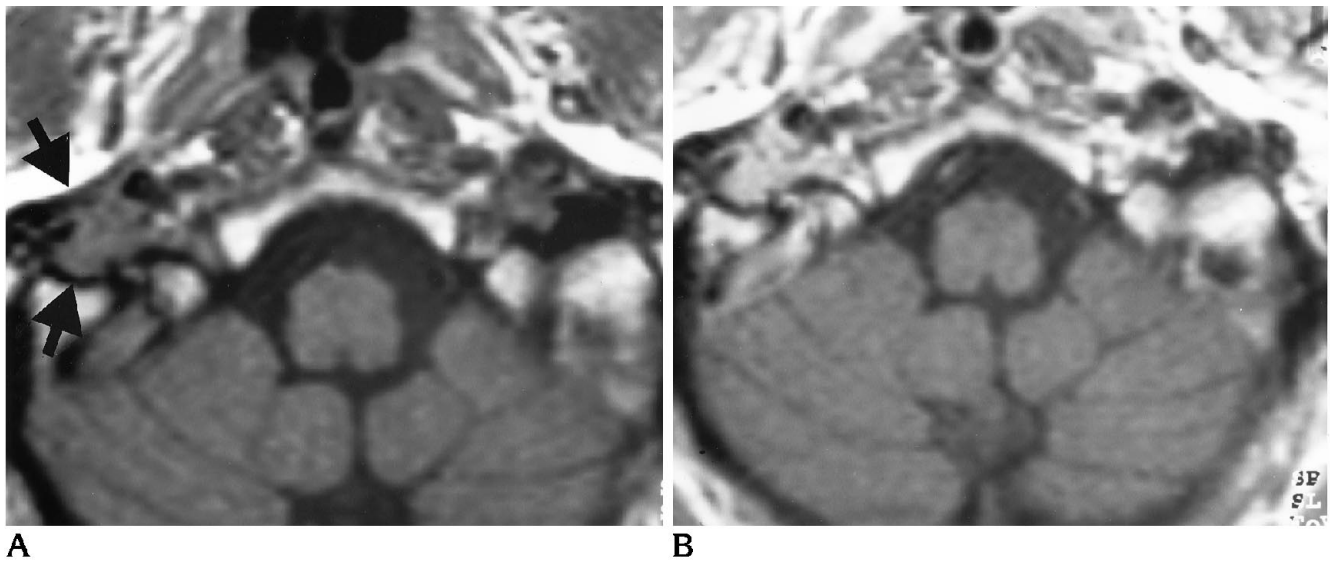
Right jugulotympanic glomus tumor. A, Spin-echo T1-weighted, 600/15/3 noncontrast axial image shows tumor involvement within the carotid sheath, jugular fossa, and bulb (arrows).
